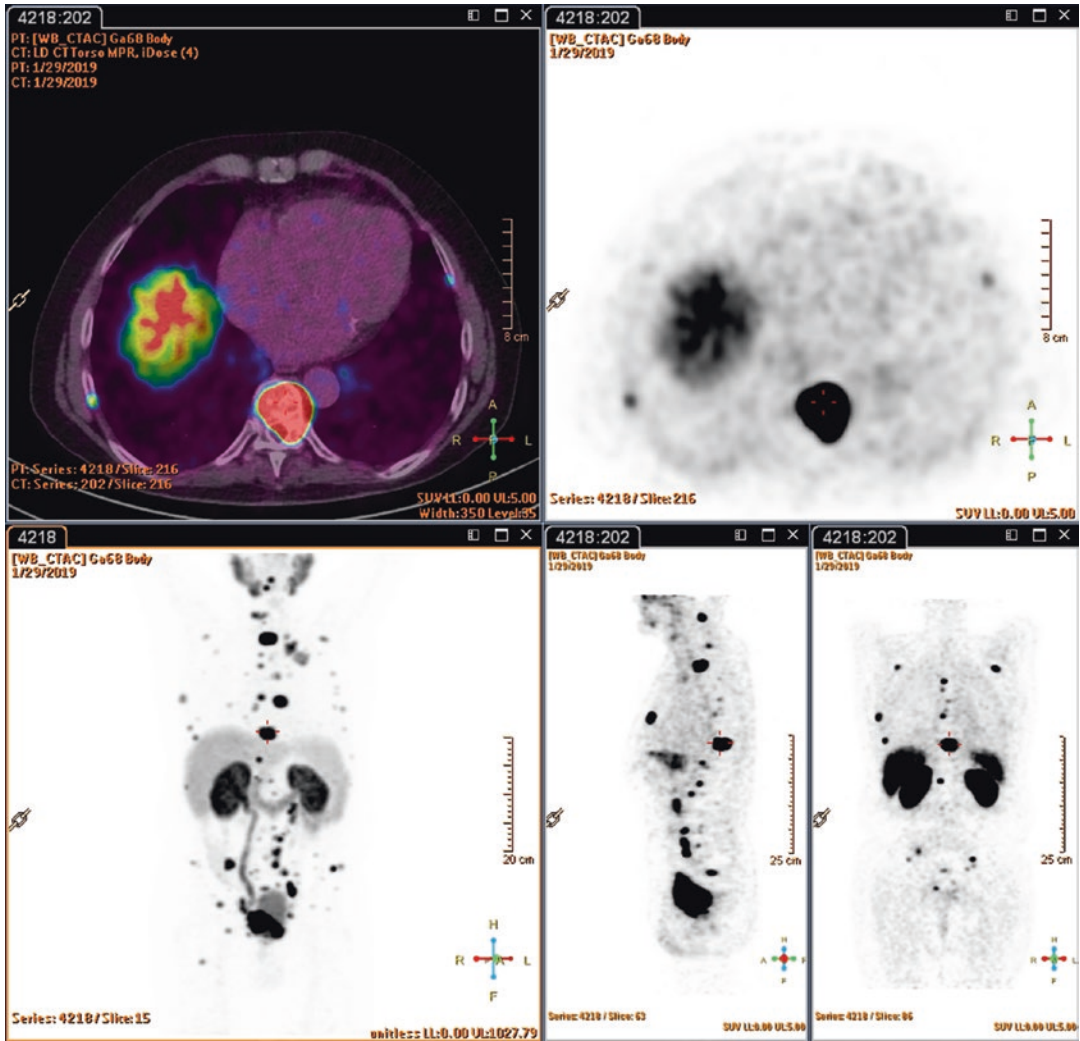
This patient presented multifocal osseous and lymph node metastases with high uptake of ^{68}Ga -PSMA. A therapeutic option with ^{177}Lu -PSMA was suggested
